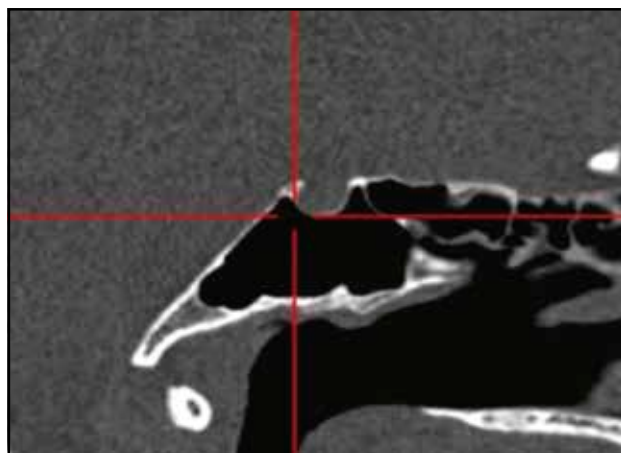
Complete sellar type pneumatization of the sphenoid sinus (cranio-facial CT scan, sagittal slice).
